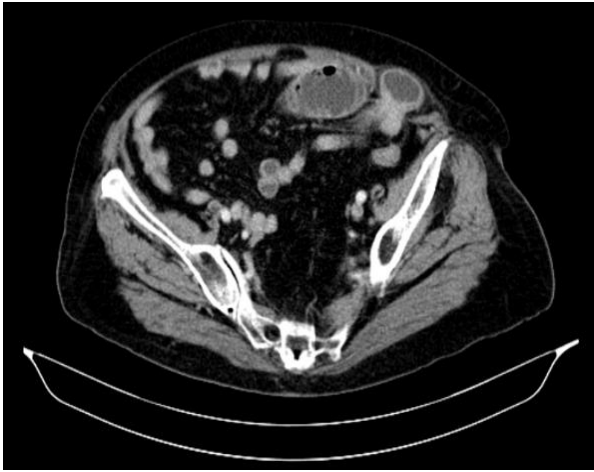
Computed tomography of incarcerated left SH with bowel content.
